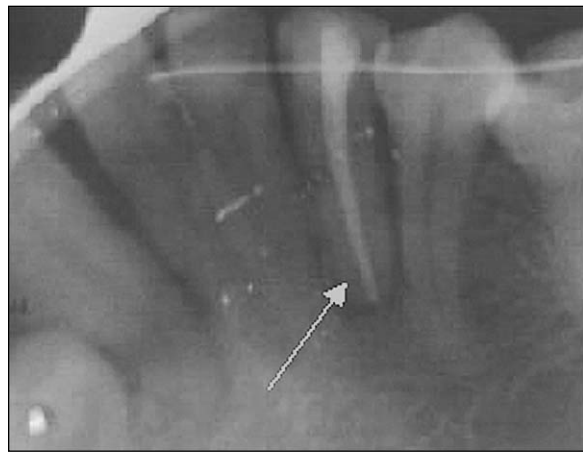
Radiograph immediately after treatment*
